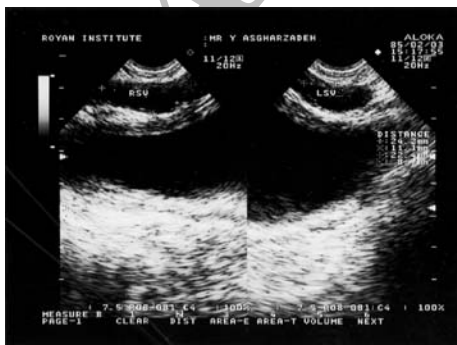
Transrectal ultrasound images of both seminal vesicles showing tortuous and cystic formation (Transverse image)
